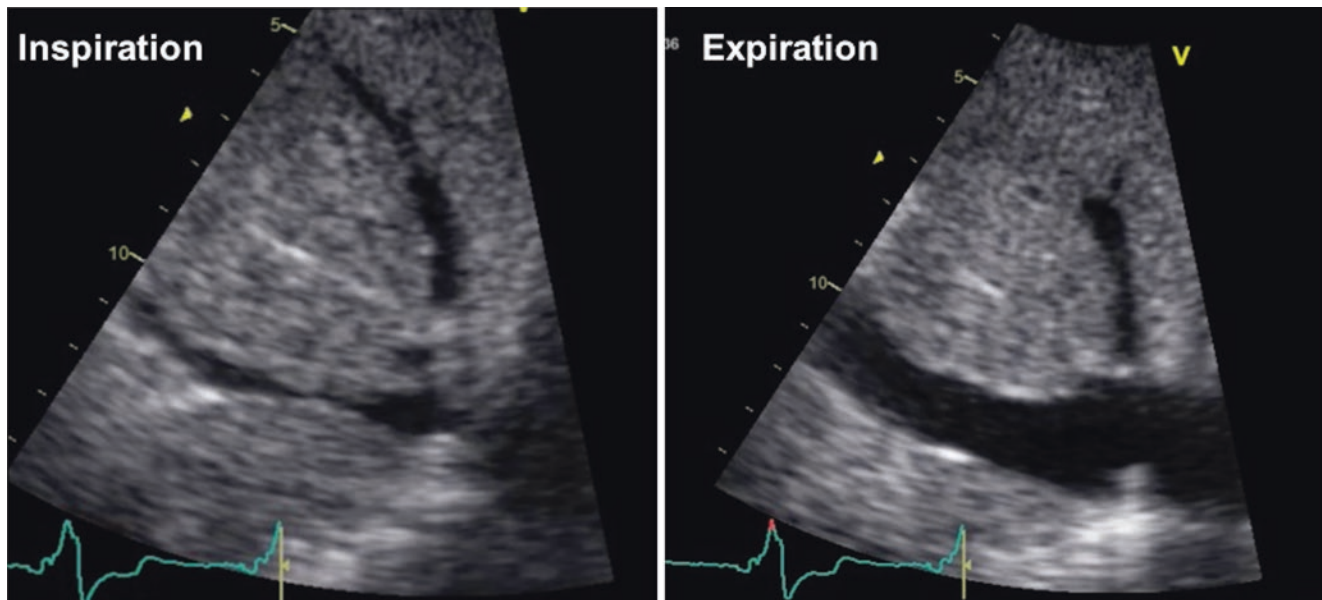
2D echocardiographic assessment of IVC showing normal inspiratory collapse. See Video 22.3. Image courtesy of Alaa M. Omar, MD, PhD
